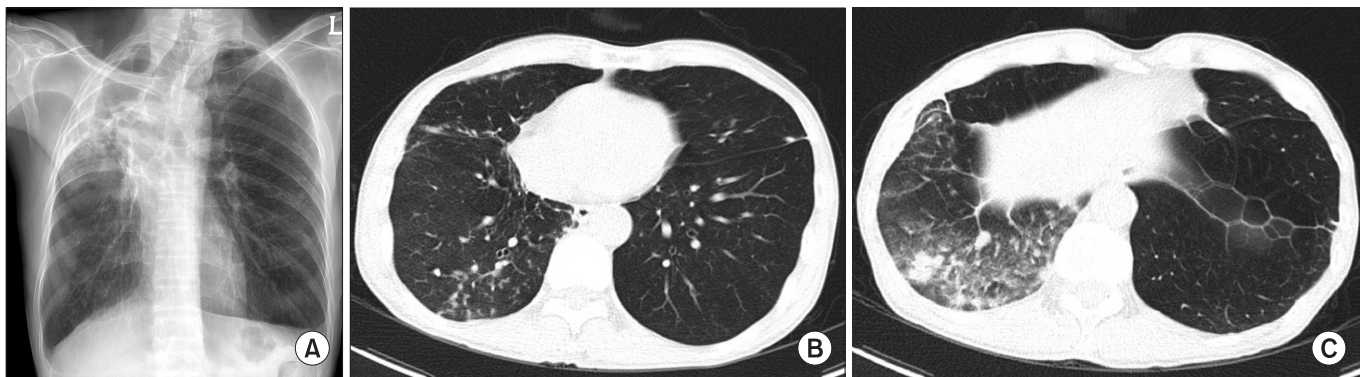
(A) Chest X-ray showing newly developed infiltrative lesions in the right middle lung area. (B) Low-dose chest computed tomography image showing newly developed segmental centrilobular nodules in the right lung. (C) Low-dose chest computed tomography image showing multifocal patches of consolidation and nodules in the right lung.
